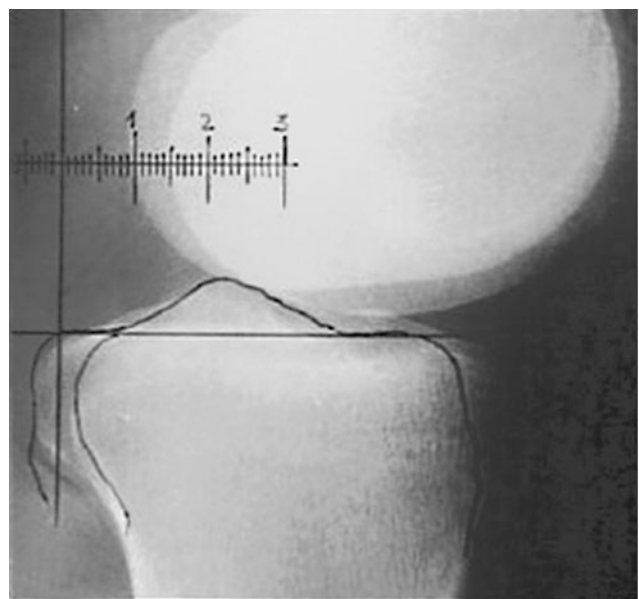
A posterior stress radiograph with a posteriorly directed force of a patient with a fixed posterior subluxation demonstrating posterior tibial displacement
